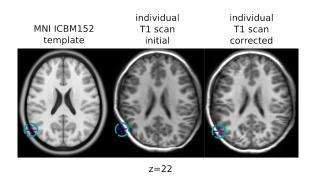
The initial coregistration of an individual MRI with the target default NIAK template space (left image) failed locally, as the meninges around the brain were pushed inside the brain (middle image). This problem was related to a poor correction of non-uniformities in the image
